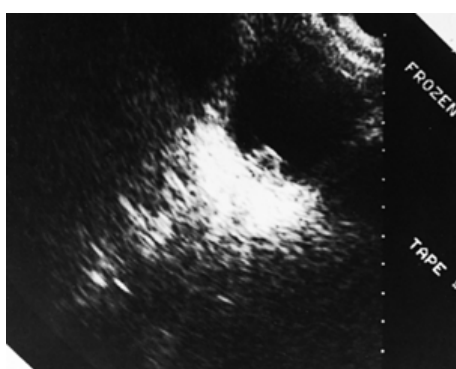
Same adolescent as in Fig. 28.2. Fungus ball and posterior bladder wall thickening and inflammation as seen on ultrasound of the bladder.
